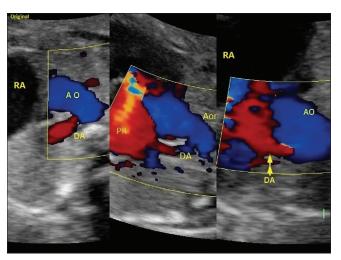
Color Doppler three-vessel views at 32 weeks (left panel), 35 weeks (middle panel), and 39 weeks (right panel) showing pulmonary regurgitation (PR) and retrograde flow in the ductus arteriosus (DA). Note the changing angle between the aorta (AO) and the DA with advancing gestation and worsening pulmonary regurgitation. RA: Right atrium. PA: Pulmonary artery
